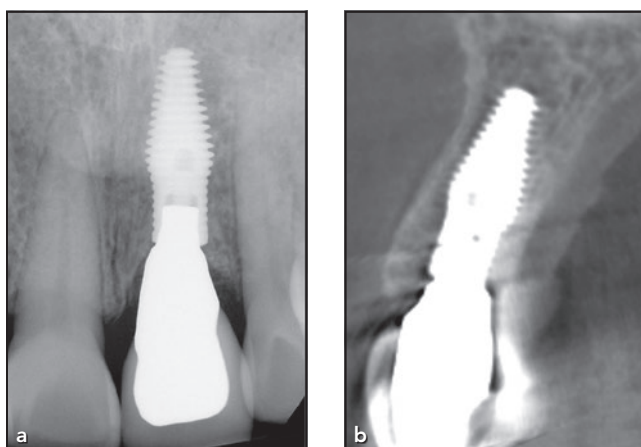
Case 1. (a) Periapical and (b) CBCT scans at 1 year show a labial bone plate thickness averaging > 2.0 mm (range: 2.3 to 3.1 mm), as well as a 2.0-mm tooth-to-implant distance.
